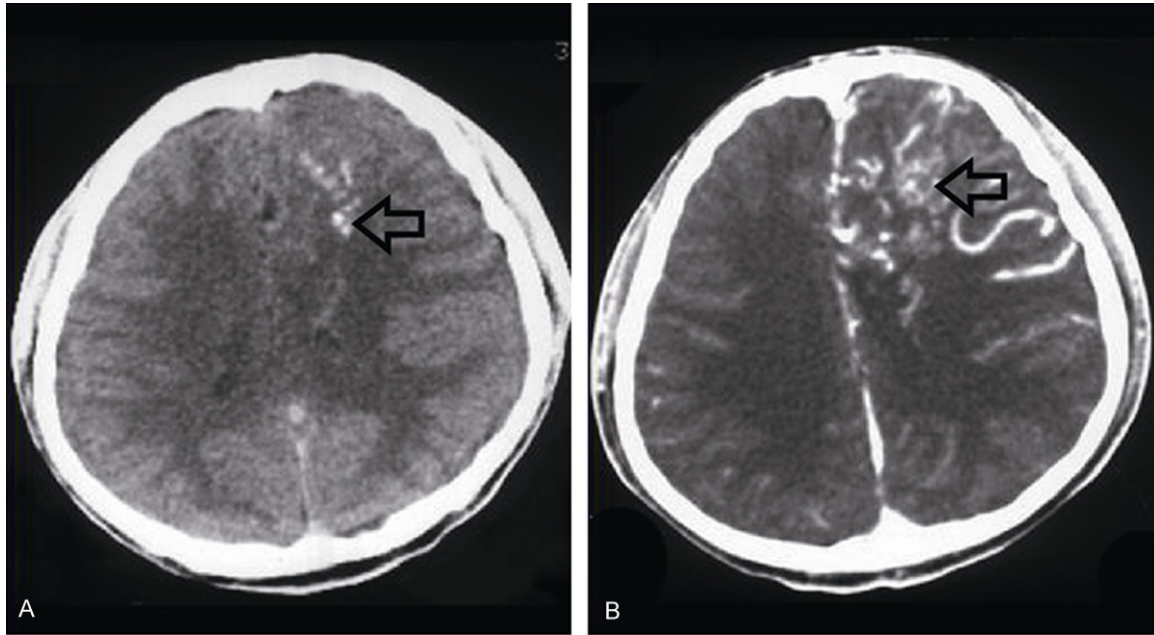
CT image of head basal ganglia aneurysm. A. CT plain scan showed isodensity; B. After CT enhanced scan, focal zone was significantly enhanced.
